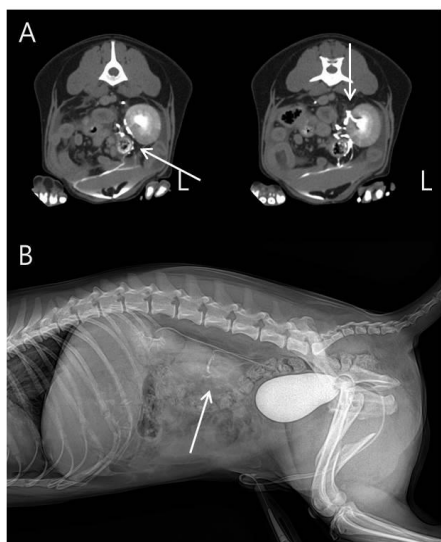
Computed tomography (A) of transverse views and radiography (B) of lateral view showing proximal left ureteral rupture and urinary leakage into the left ventral abdominal cavity retroperitoneal space.
